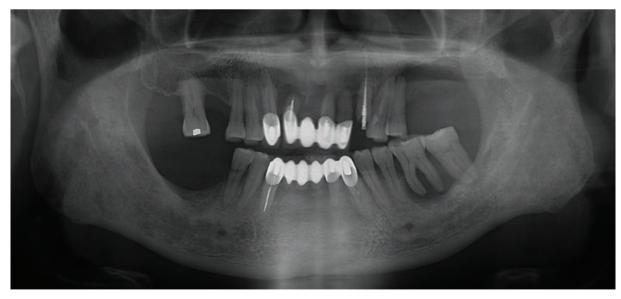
Panoramic radiograph at initial examination Alveolar bone loss is observed in multiple teeth and the post is exposed at #23 due to crown fracture.
